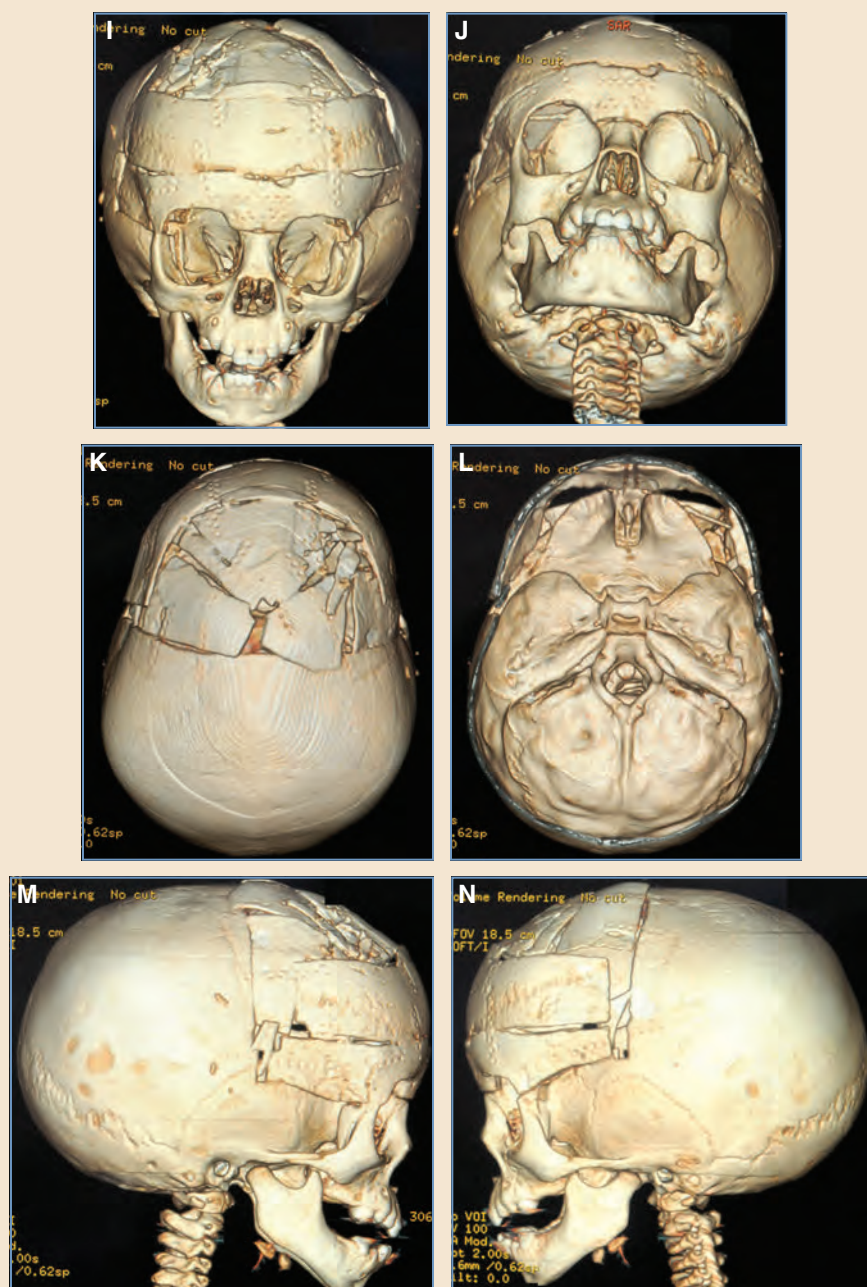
cont'd I-N, Immediately postoperative CT images. The extent of surgery depends on the craniofacial deformity. This procedure involved removing the supraorbital rim and temporal attachment (bandeau) with subsequent reshaping. A symmetrical orbital aperture was created with a combination of contouring and reshaping maneuvers.
